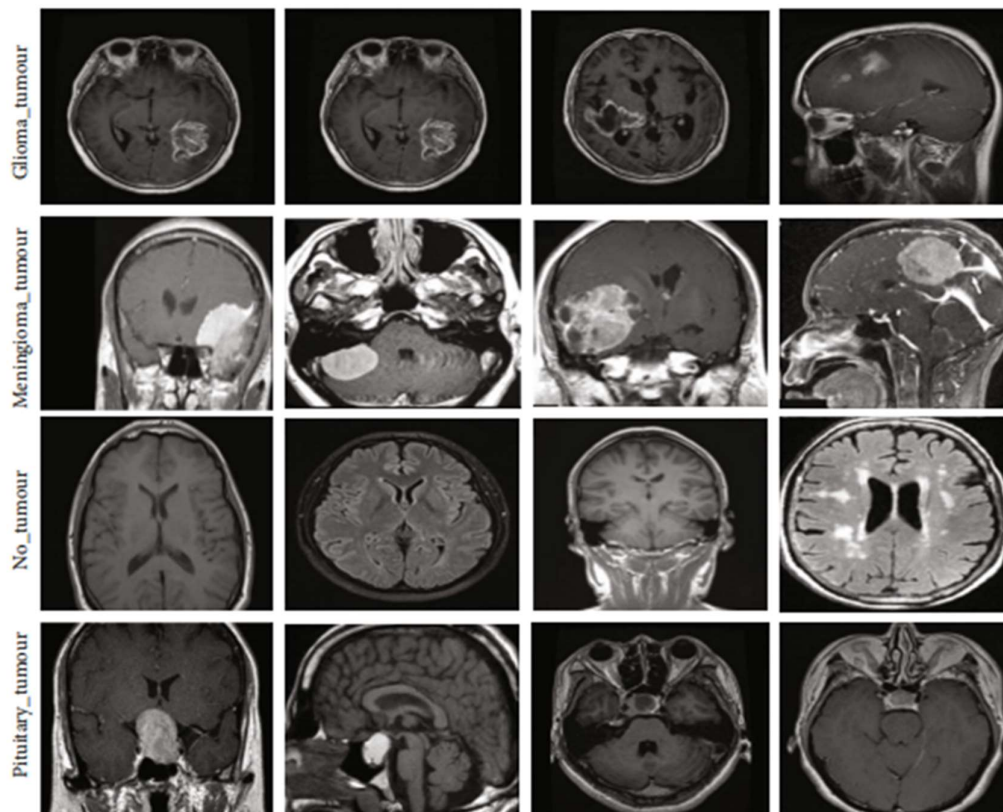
Samples of a dataset of an MRI of brain tumors.
